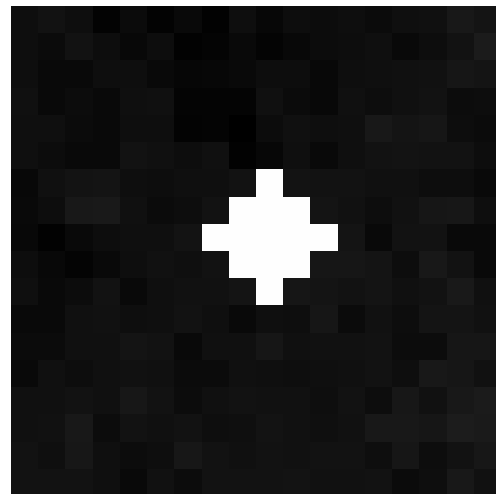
Comparison of the outlier filters for added 3x3 block impulse noise of frequency 0.1%. Both the standard deviation and star-shaped filters (b) and (c) performed poorly for this type of noise. Although there are some obvious impulses remaining in the filtered radiograph, the results for the MAD-based outlier filter were much better than the results for the two other filters.
